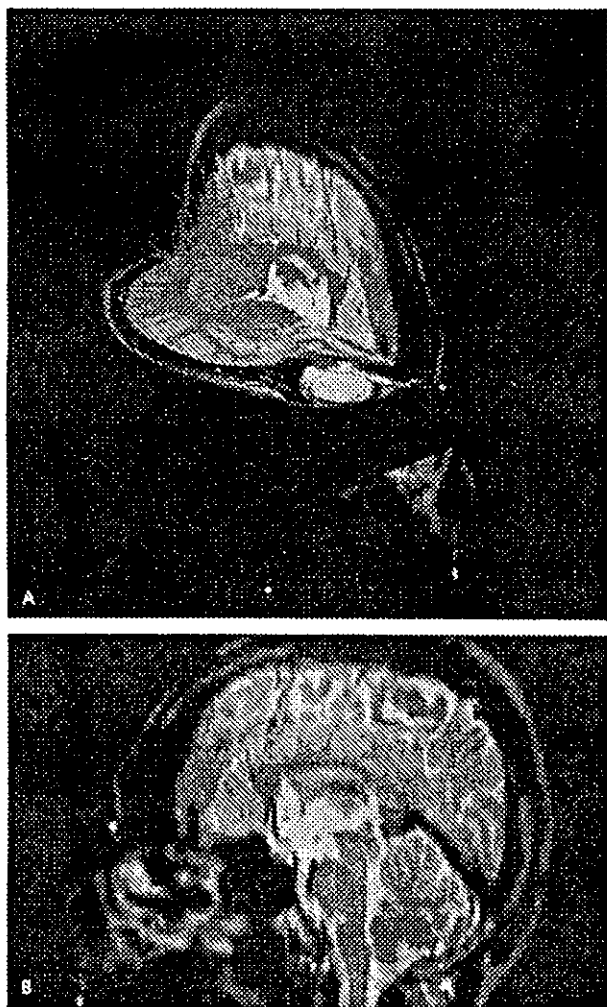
Diffusion tensor tractography through the caudal portion of the body and splenium of the corpus callosum. A, Three-dimensional projections of the tracking lines overlaid on axial and sagittal T2-weighted fast spin echo images. The lines that entered posterior temporal white matter (tapetum) crossed through the ventral portion of the splenium of the corpus callosum (shown in red). B, In-plane location overlaid on a sagittal T2-weighted fast spin echo image. In the splenium of the corpus callosum, the lines representing the tapetum were surrounded by the lines that reached parieto-occipital white matter (forceps major, shown in blue) and were clearly distinguished.
